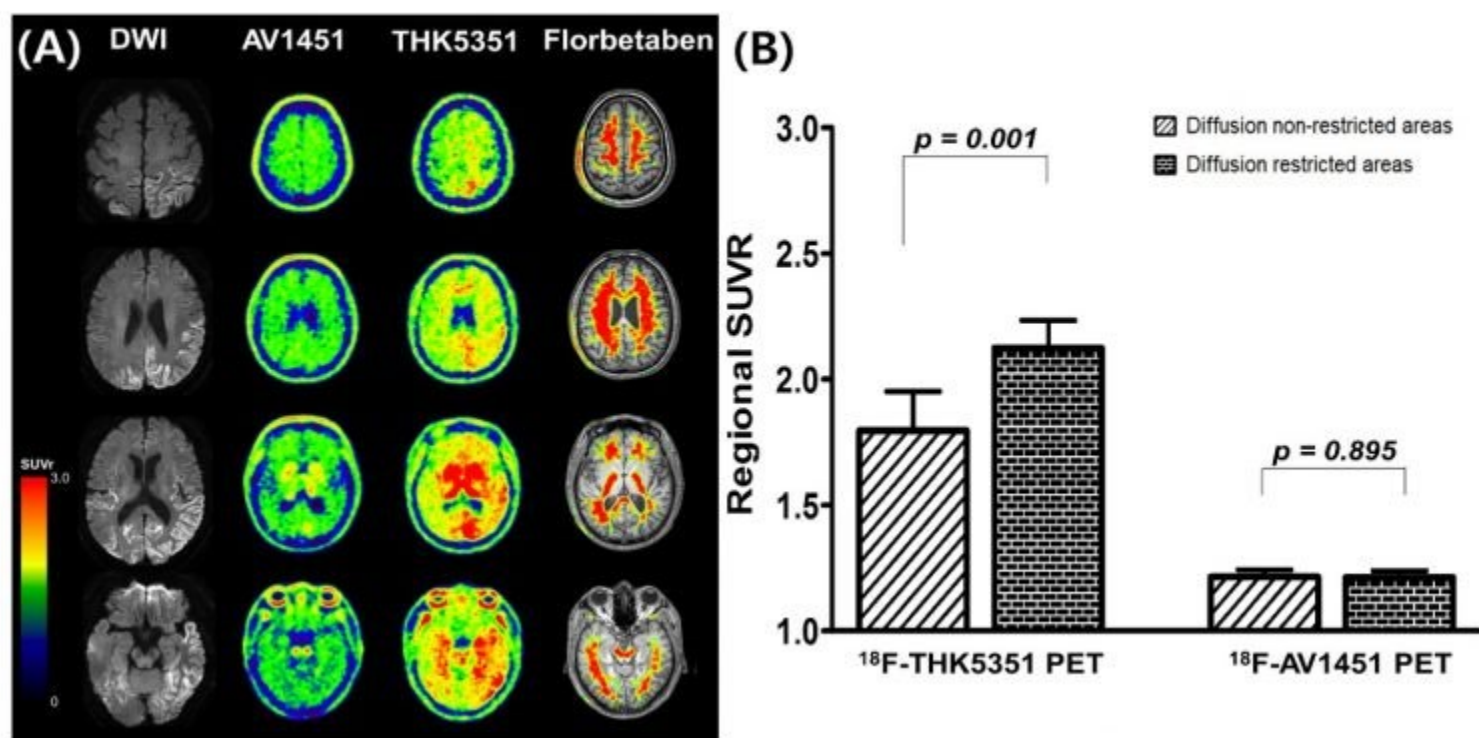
(A) Diffusion weighted images (DWI), tau (AV-1451 and THK-5351), and amyloid (florbetaben) PET images. (B) Regional SUVR of THK-5351 and AV-1451 in diffusion non-restricted and restricted areas.
